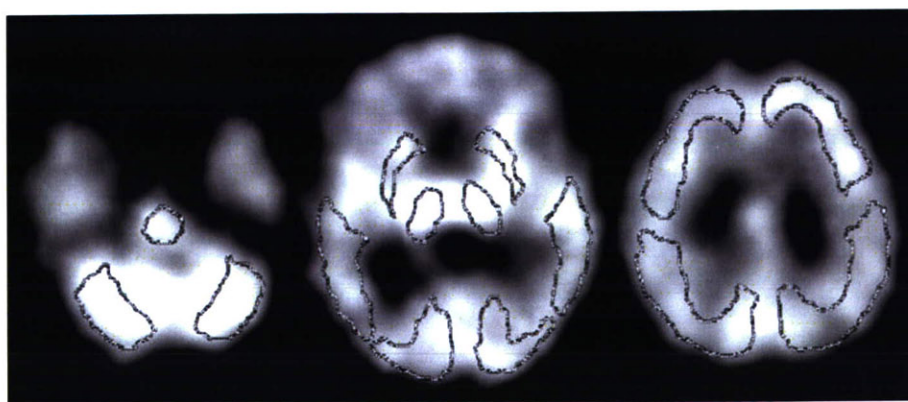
SPECT images of a healthy volunteer which show radioactivity collected 0 to 40 min after injection of ^{123}I -5-iodo-3-(2(S)-azetidinylmethoxy) pyridine, and the volumes of interest (VOIs). VOIs were placed in the thalamus, striatum, brainstem, cerebellum, and the frontal, temporal, parietal, and occipital cortices.
